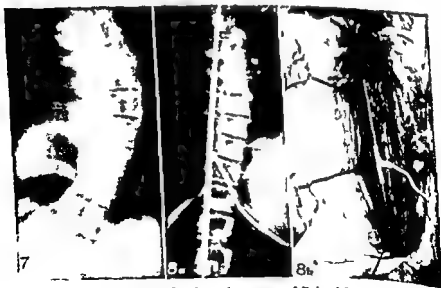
Frontal roentgenogram of Patient 2
